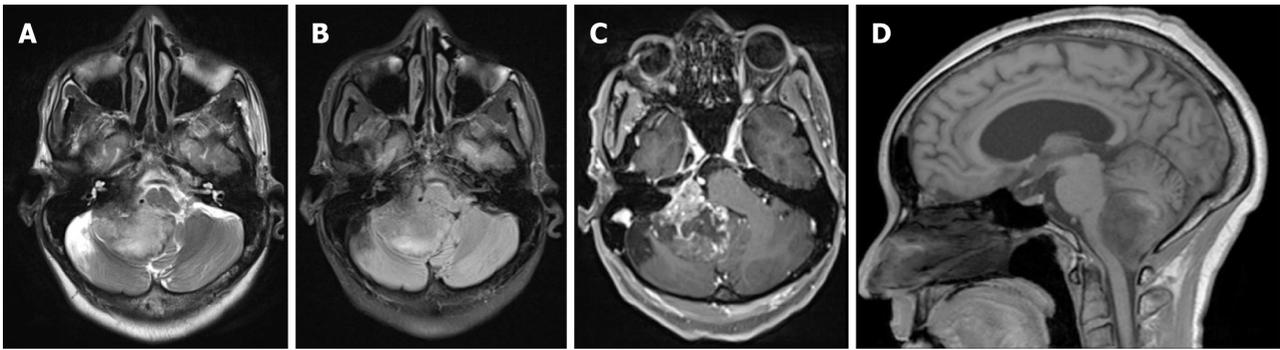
Right cerebellar pontine angle tumour with inferior extension to the craniocervical junction, anterior effacement, and compression of the cervical cord. A: T2-weighted axial image; B: Fluid-attenuated inversion recovery axial image; C: T1-weighted fat suppression gadolinium axial image; D: T1-weighted sagittal image.
